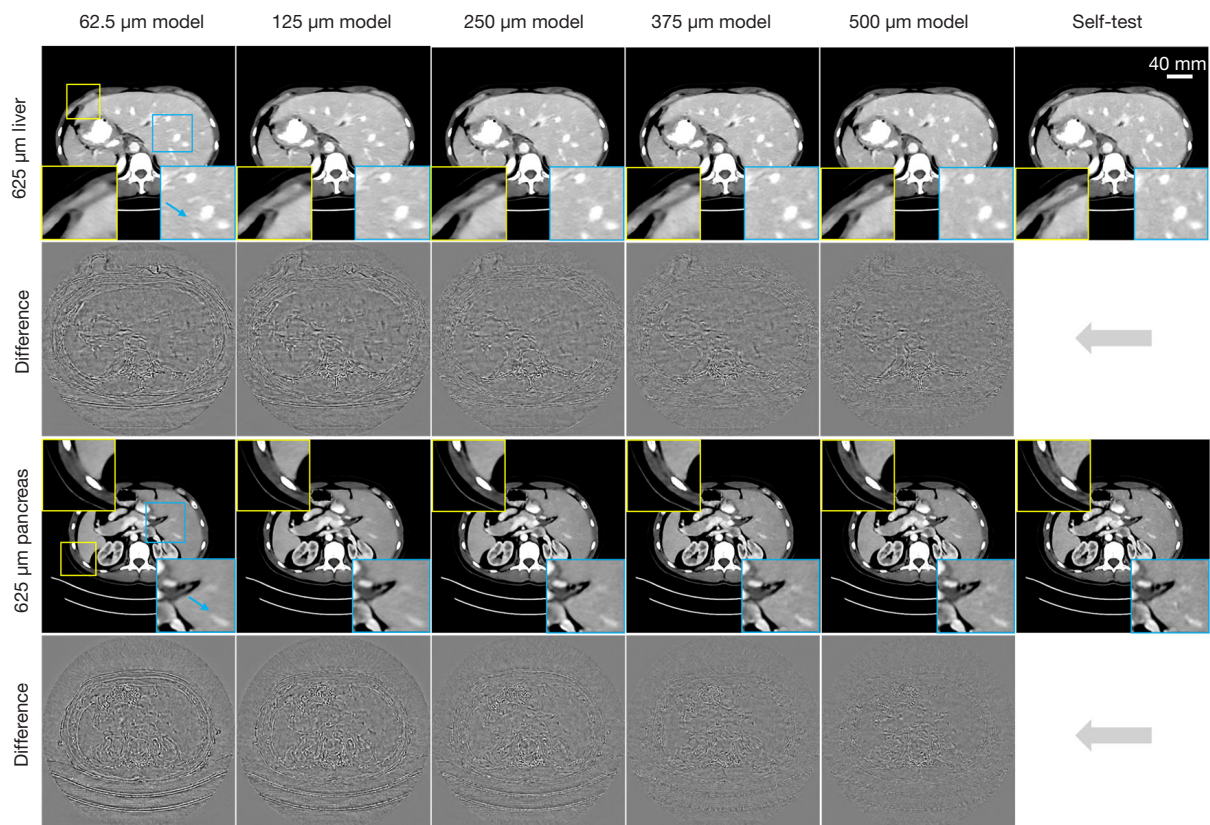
The U-Net test results of 625 μm CT images. The layout of these images is similar to *Figure 4*. The display window of test images is $[0.20, 0.24] \text{ cm}^{-1}$ and the display window of residual images is $[-0.007, 0.007] \text{ cm}^{-1}$. The scale-bars denote 40.0 mm. CT, computed tomography.
